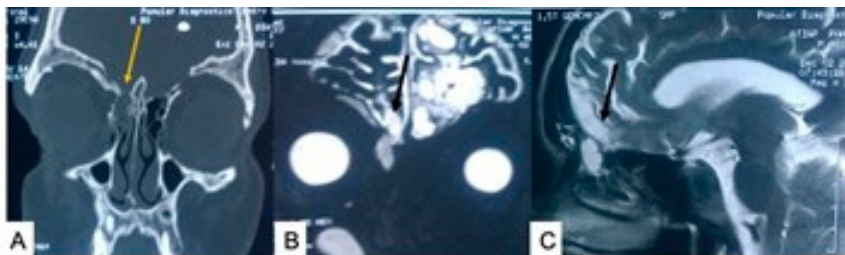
(A) CT scan coronal image of bony window showing traumatic fractures (right side) resulting in CSF fistula. (B,C) MR cisternograms (with a coronal image and a sagittal image, respectively) showing CSF tract through the same defect seen in CT. Source: Figure by authors.
